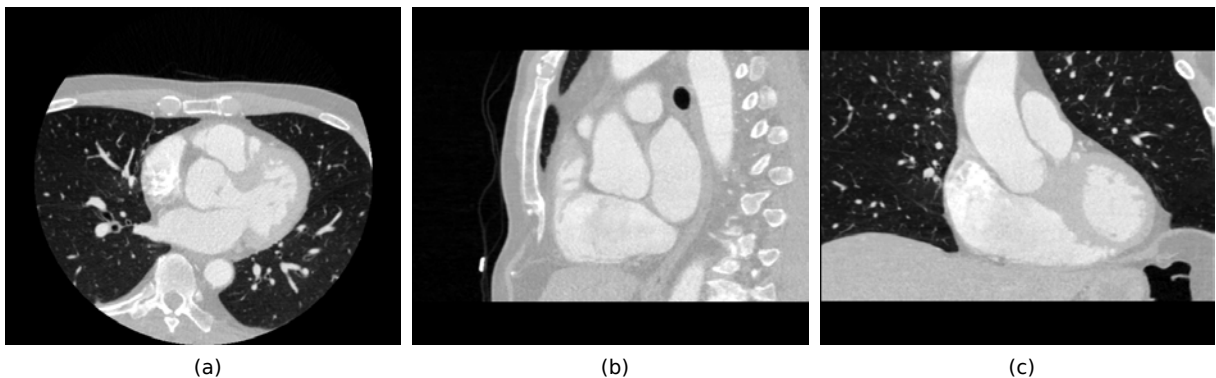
Thorax from the superior vena cava to the stomach. Axial (a), Sagittal (b) and Coronal (c) views of the CT dataset.
